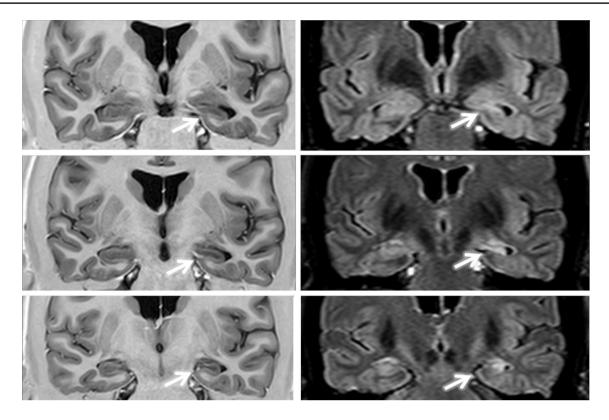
MRI from a patient with left mesial temporal lobe epilepsy with hippocampal sclerosis. Coronal T1-Inversion recovery (*left panel*) and FLAIR (fluid-attenuated inversion recovery) images showing typical MRI signs of HS (*arrows*). The left hippocampus
